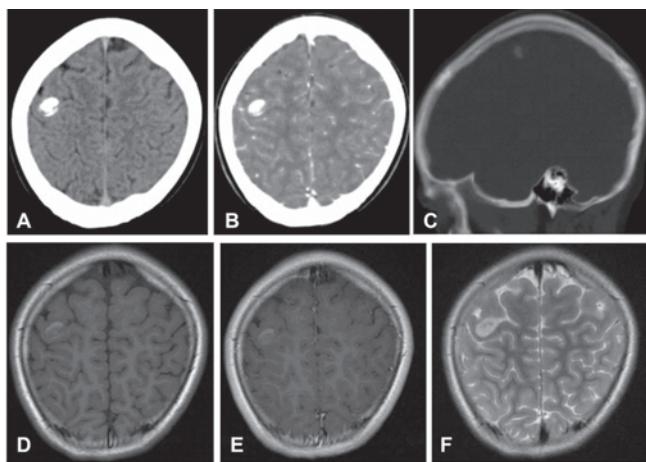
Neuroimaging. Right intra-axial lobe frontal-precentral partially calcified lesion, computed tomography (A, simple; B, contrast and C, sagittal bone window) and magnetic resonance imaging (D, axial T1 weighted, E, Axial T1 weighted with contrast and F, axial T2 weighted), measure 12.9x11.3x14.3 millimeter, anterior-posterior, superior-inferior and transversal, respectively.
